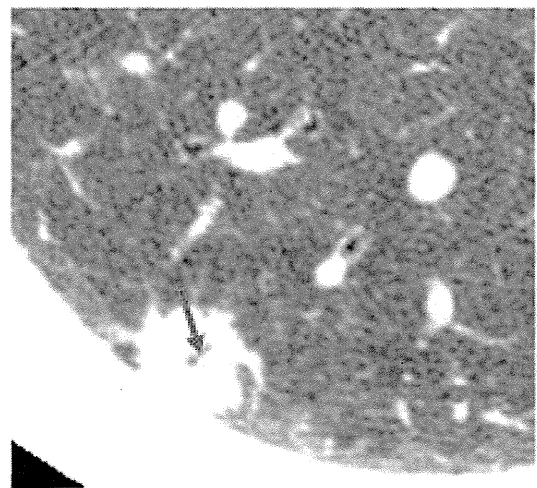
Adenocarcinoma with air bronchogram in a 65-year-old woman. Thin-section CT demonstrated a solid nodule of 15 mm with air bronchogram (arrow). Pathology confirmed it was non-mucinous minimally invasive adenocarcinoma without lymphatic or vascular invasion.
